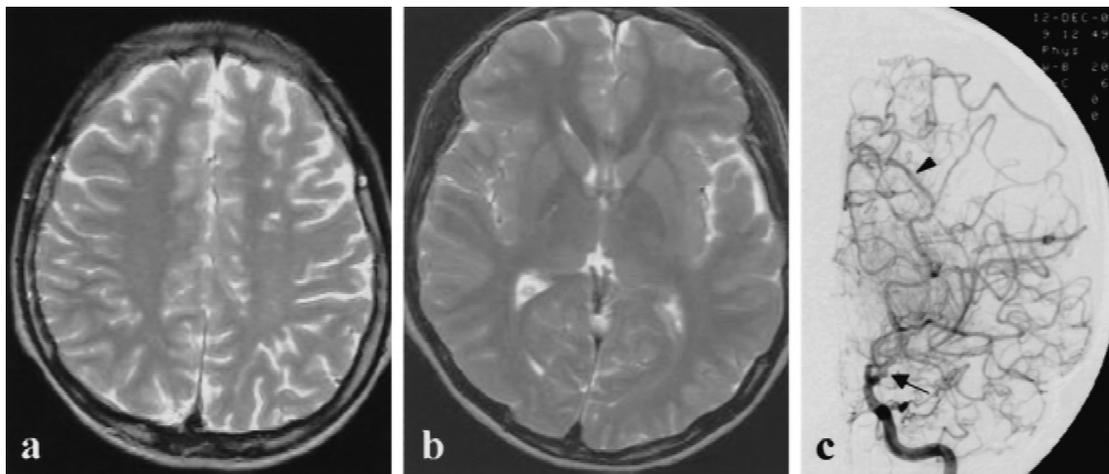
T2-weighted MR imaging showing multiple small high signal intensity lesions in the centrum semiovale in the left frontal lobe (a). There was no basal ganglia lesion (b). Left internal carotid angiogram (c), anteroposterior projection, demonstrating near complete occlusion of ICA at the supraclinoid portion (arrow). Note the fine scanty basal collaterals suggestive of moyamoya vessels, and the leptomeningeal collateral flow from the PCA (arrowhead).
